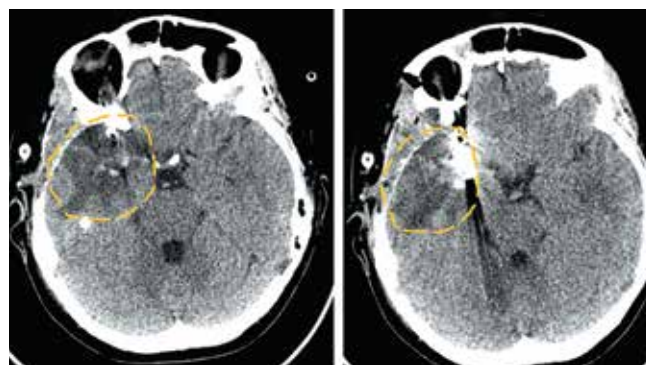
Computed tomography of the brain of patient 5 after clipping of the M1–M2 segments aneurysm of the right middle cerebral artery. The zone of ischemia of the anterior parts of the right temporal lobe is marked with an orange dashed line
